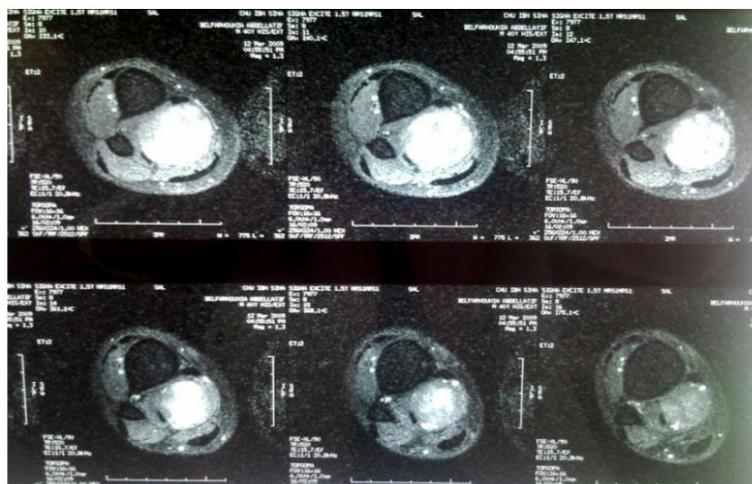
MRI signs of schwannoma.
